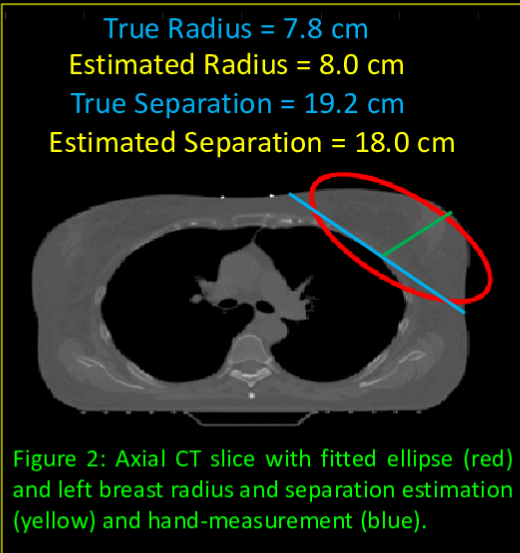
Axial CT slice with fitted ellipse (red) and left breast radius and separation estimation (yellow) and hand-measurement (blue).
